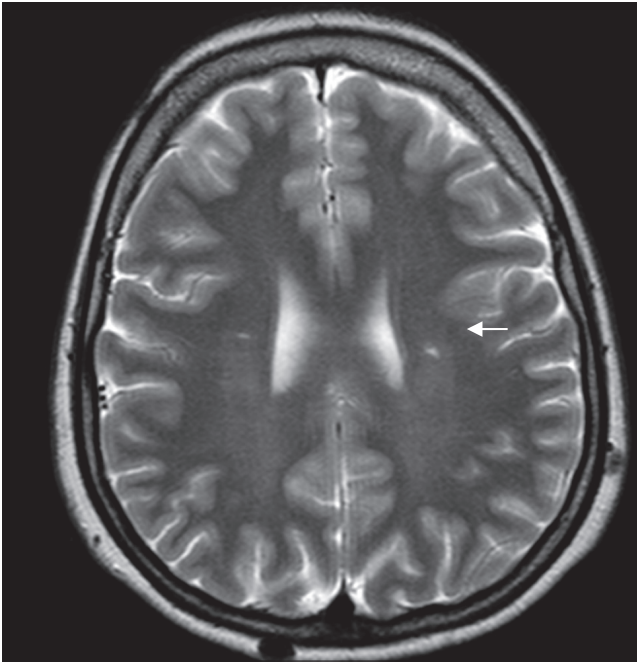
Brain computed tomography scan. Cerebral ischemia. Ischemic lesion in the left parietal lobe (arrow)
